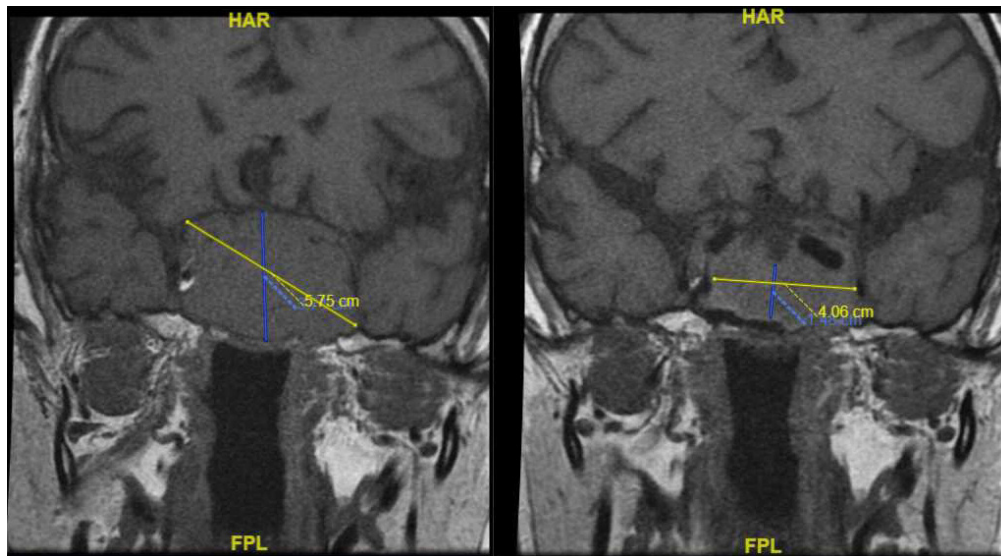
On the left. pre-treatment sella MR and on the right. 3 months after the treatment sella MR image is seen.
